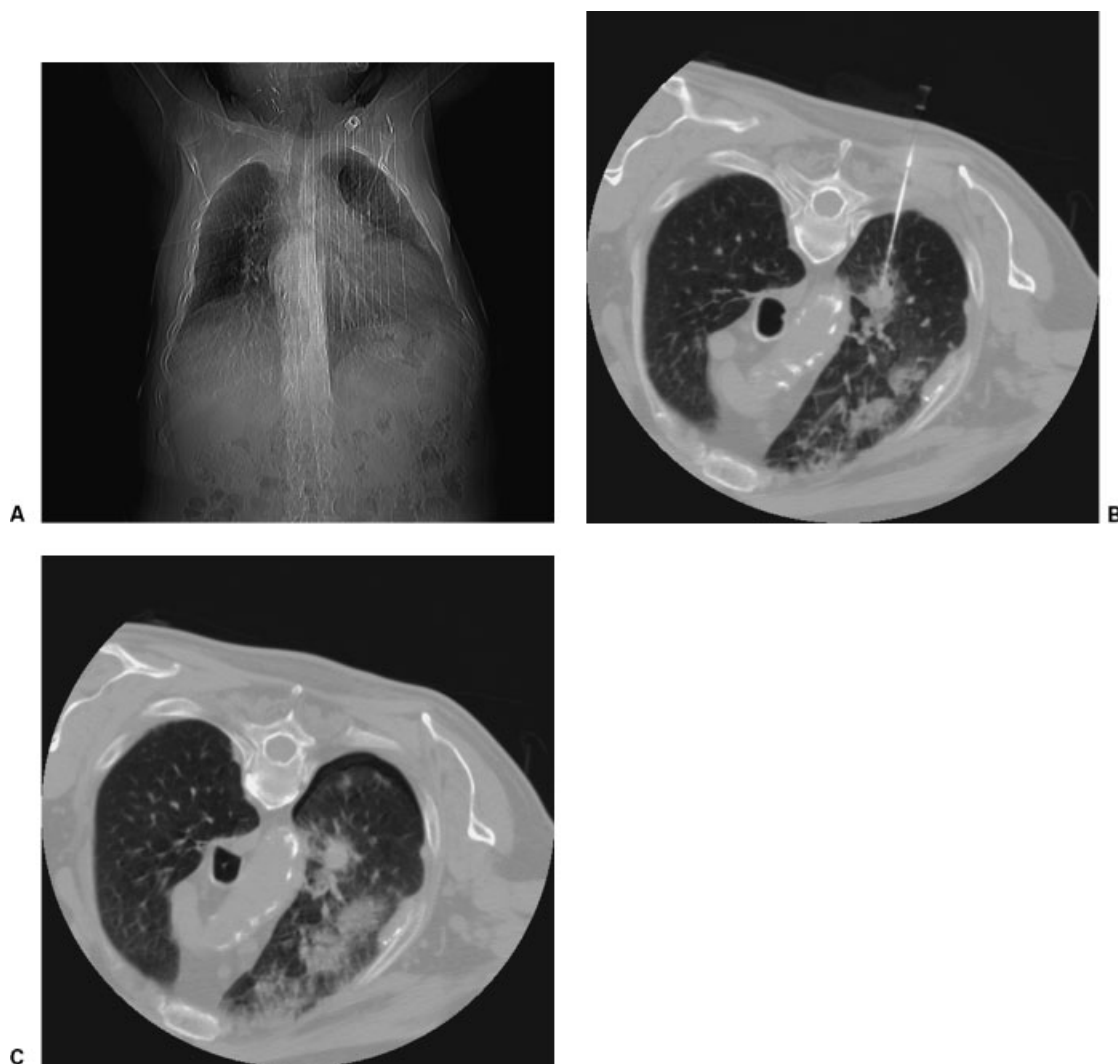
Lung biopsy. (A) Initial scout view shows skin localizing grid over left lung apex. (B) Computed tomography (CT) image shows 18-gauge trocar needle in mass. (C) CT image after needle removal demonstrates small pneumothorax.
